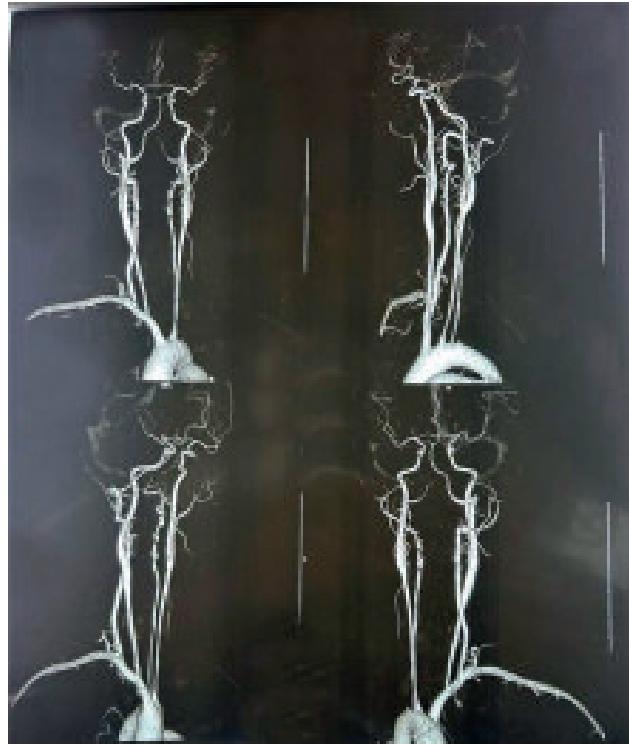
CT angiography of carotid and vertebral arteries showing smooth narrowing of the left common carotid and left subclavian arteries
